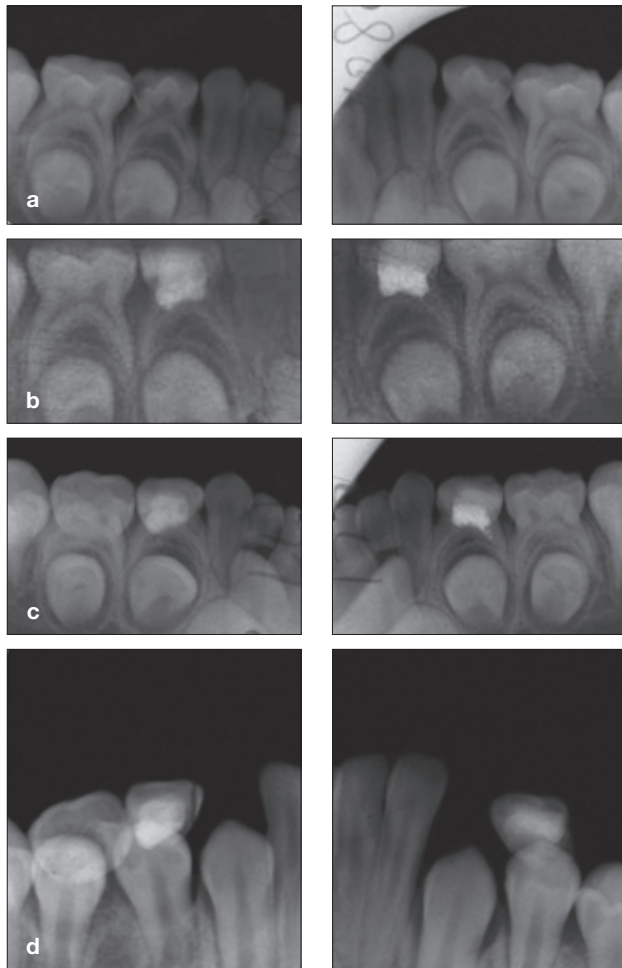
MTA (left column) and CH (right column) pulpotomies were performed on contralateral first primary molars. Both teeth showed success after 54 months. Radiographs taken: a) before operation; b) immediately after pulpotomy; c) 11 months after pulpotomy; and d) 54 months after pulpotomy. At 54 months the roots of the primary first molars were resorbed completely and the successor permanent teeth were erupting.
